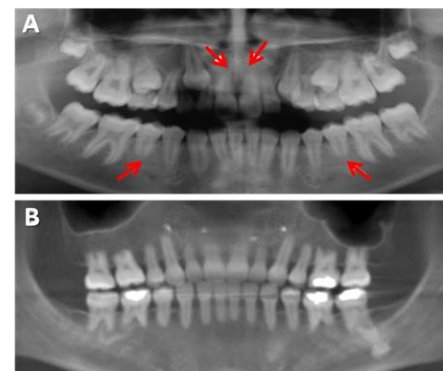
Panoramic radiographs from a patient with (A) localized SRA (arrows) and (B) generalized SRA
